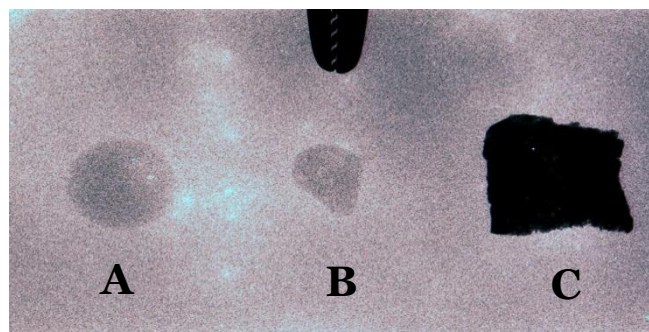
Radiopacity of Alg/Sr beads in X-ray Radiograph (A, B). Hydroxyapatite material (C).
